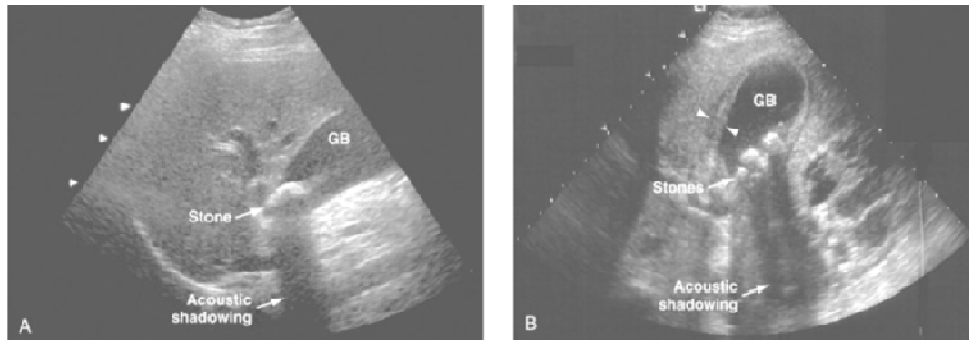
(A): Typical ultrasonographic appearance of cholelithiasis. A gallstone is present within the lumen of the gallbladder (GB), casting an acoustic shadow.
